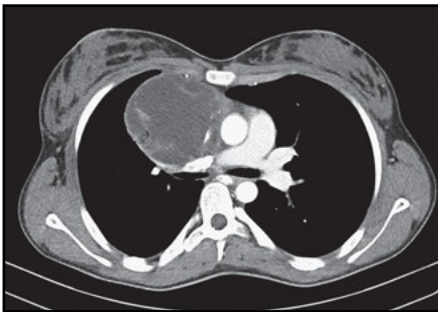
CT scan of a mediastinal teratoma.
